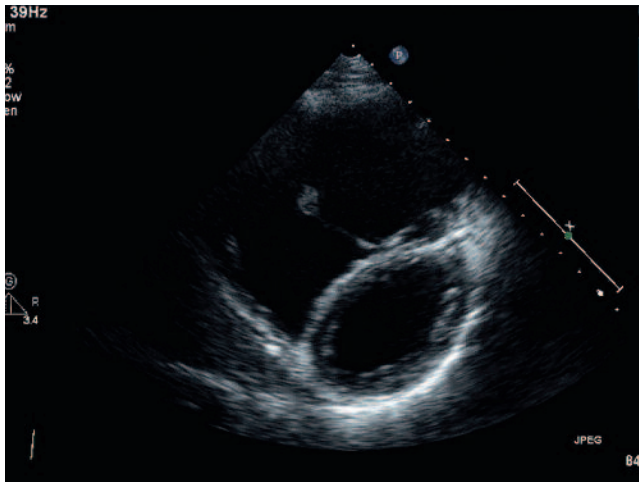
Parasternal short-axis echocardiography showing volume-overloaded right ventricle.
